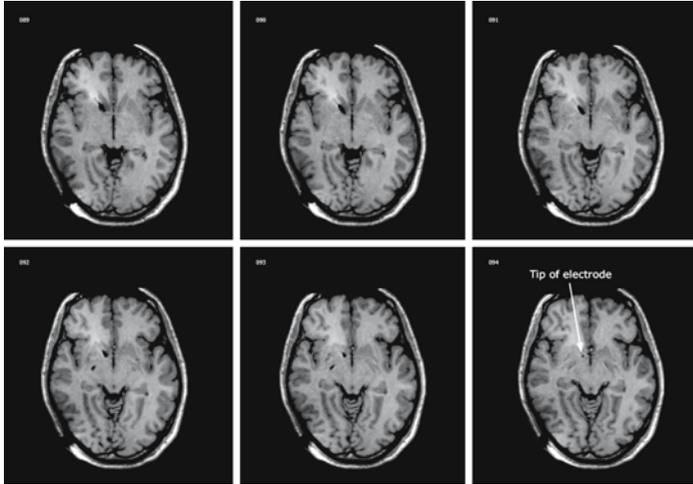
Postoperative T1-weighted MRI depicts exact electrode placement in the desired target area. Note the dark artifact surrounding the electrode, which is due to disturbance of the local magnetic field by the electrode and not caused by tissue damage
